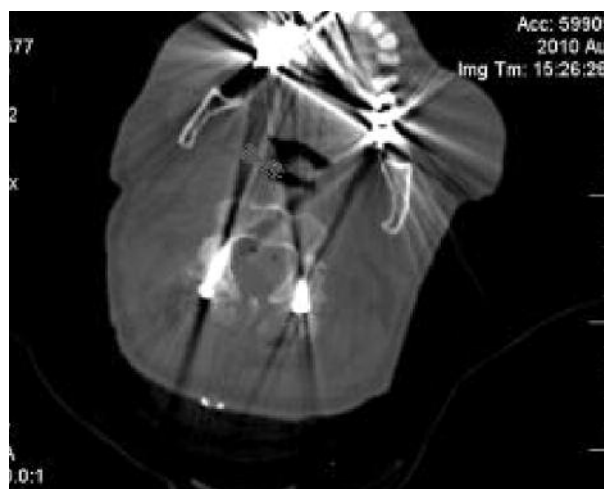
An axial CT scan showed minor breach of the right pedicle screw .
